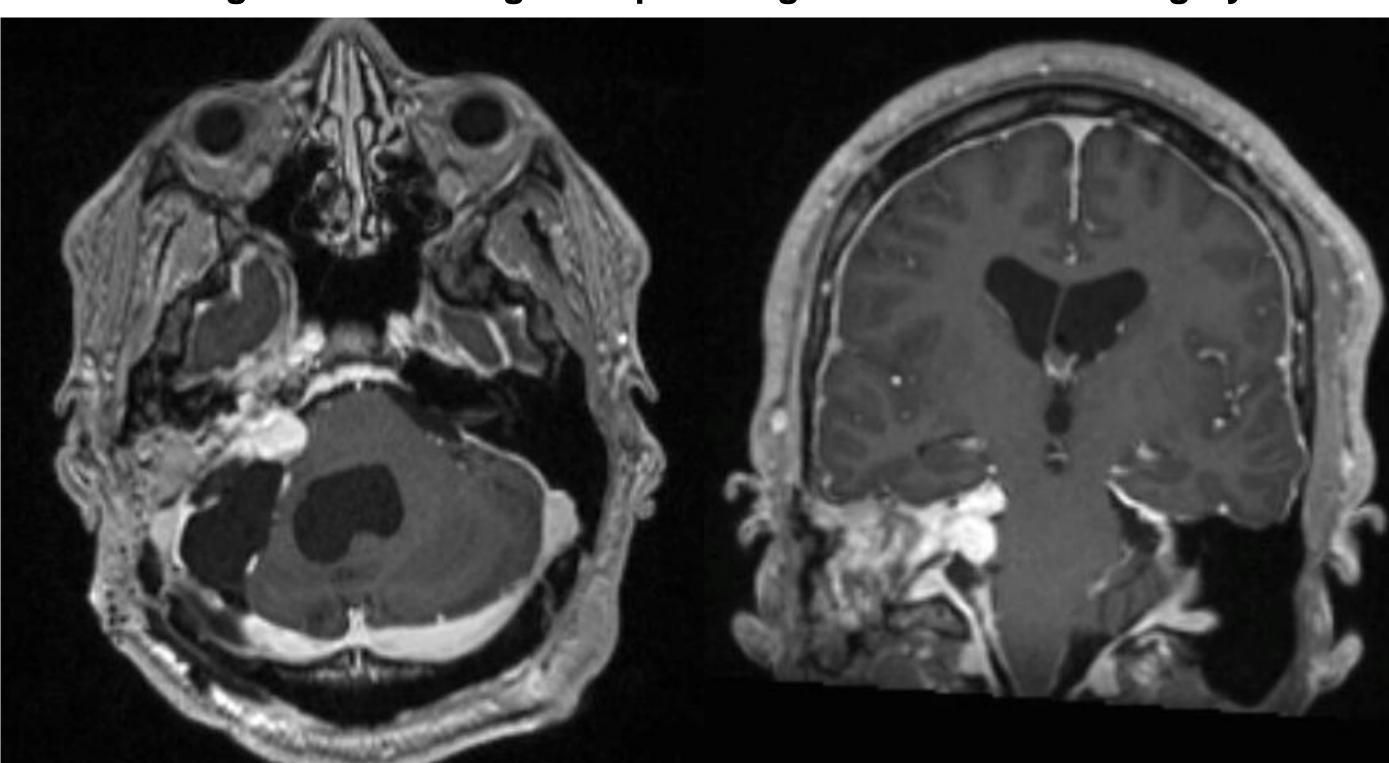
Axial (A) and coronal (B) T1W post-contrast IR-SPGR MRI images of residual vestibular schwannoma after translabyrinthine debulking. Note improved, but persistent brainstem compression and large extent of residual tumor.
